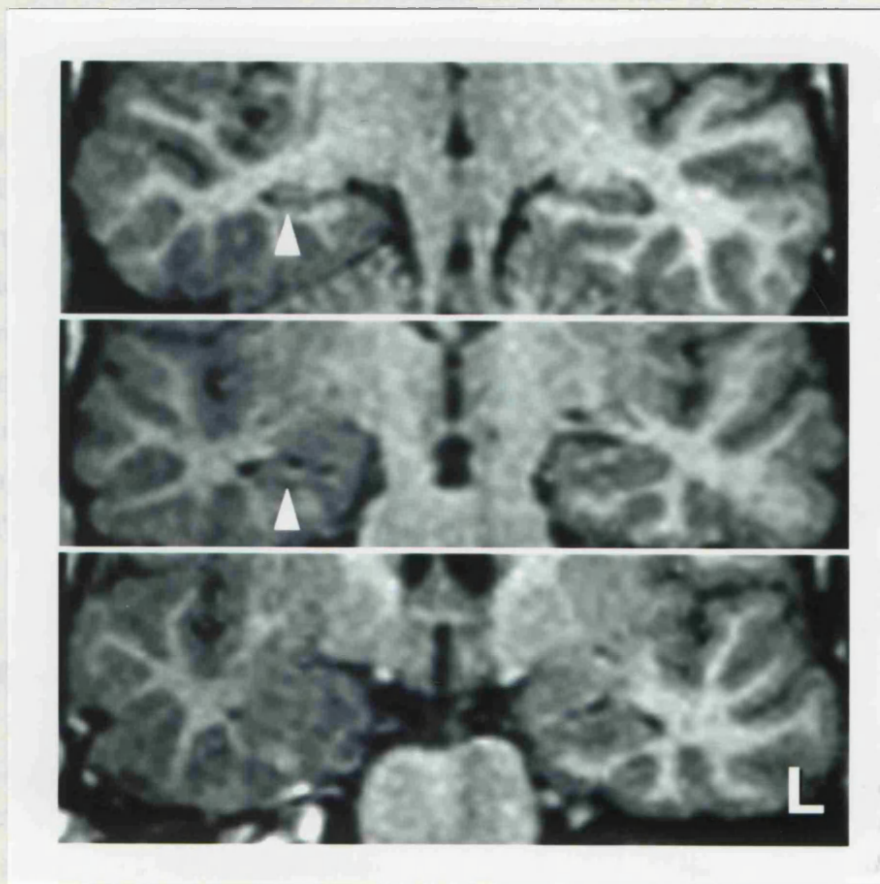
Dual pathology: the combination of HS and CD. Patient was a 31 year old man with intractable TLE. He had a history of prolonged FC at the age of 2 years. MRI showed dual pathology, i.e. right HS (white arrows) and marked CD of the right temporal lobe. The right temporal neocortex was thickened, and the white matter had an abnormal appearance compared with the left (L) side.
